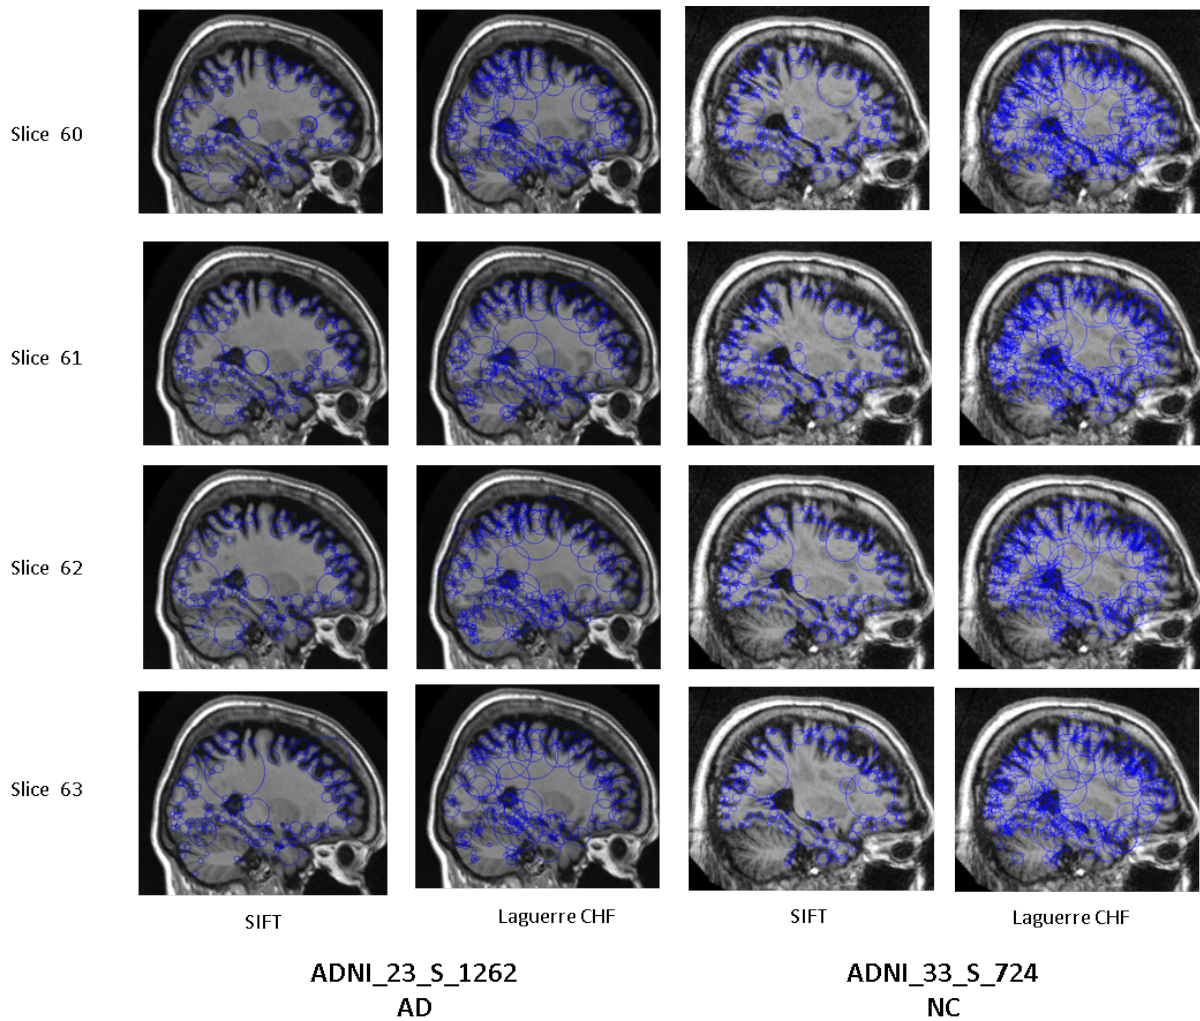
Example of features placement in MRI slices (from slice number 60 to slice number 63), extracted features here are SIFT and CHF's
